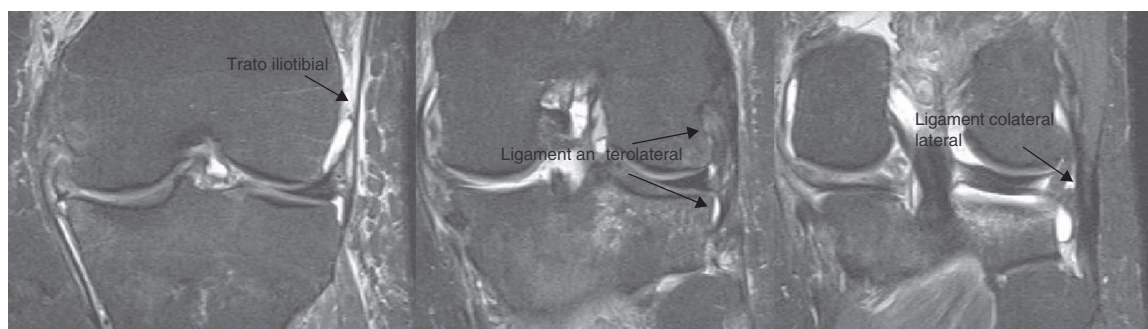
Coronal fat-suppressed T2-weighted imaging of a 38-year-old male after trauma. The anterolateral ligament is arising from the femur with two insertions, the lateral meniscus and the tibia. It is located dorsal to the iliotibial tract and ventral to the lateral collateral ligament.
